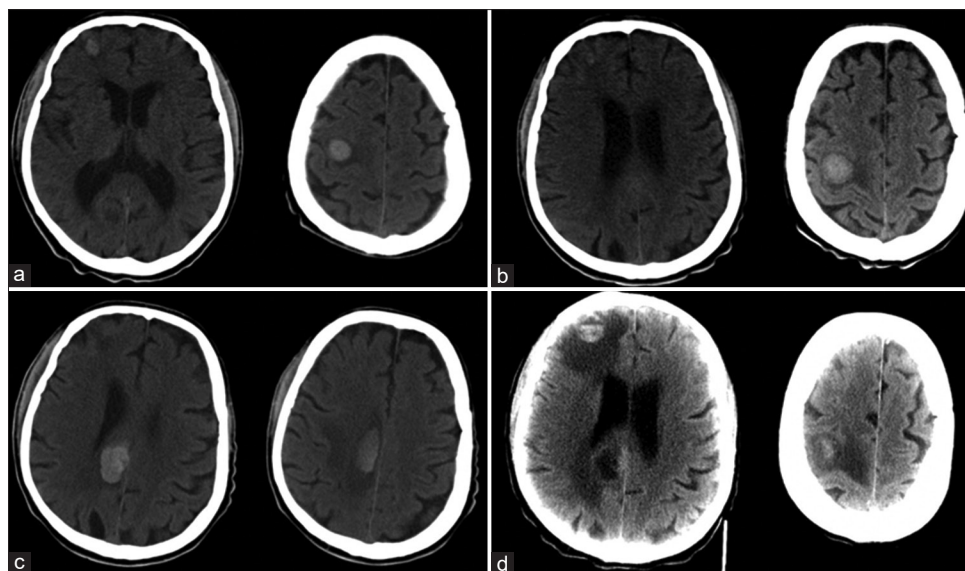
CT images showing the evolution of the hemorrhagic picture. The first two hemorrhagic spots in the right frontal site (a), and the evolution of the lesion after 5 days (b). After 10 days, a new right subcortical paramedian hemorrhage appears (c). The last two hemorrhages at the same site as the first lesion. It is possible to note the presence of a fluid level in the context of the frontal lesion (d). CT: Computed tomography
